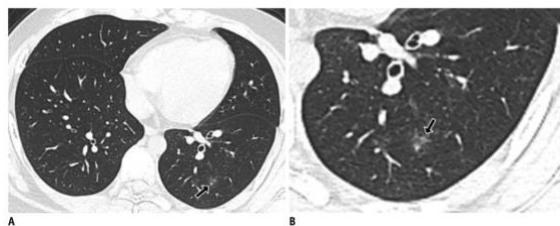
12-year-old girl diagnosed with COVID-19. Small patches of ground-glass opacity were observed on CT scan, with subpleural distribution and bilateral lung involvement (arrows).
